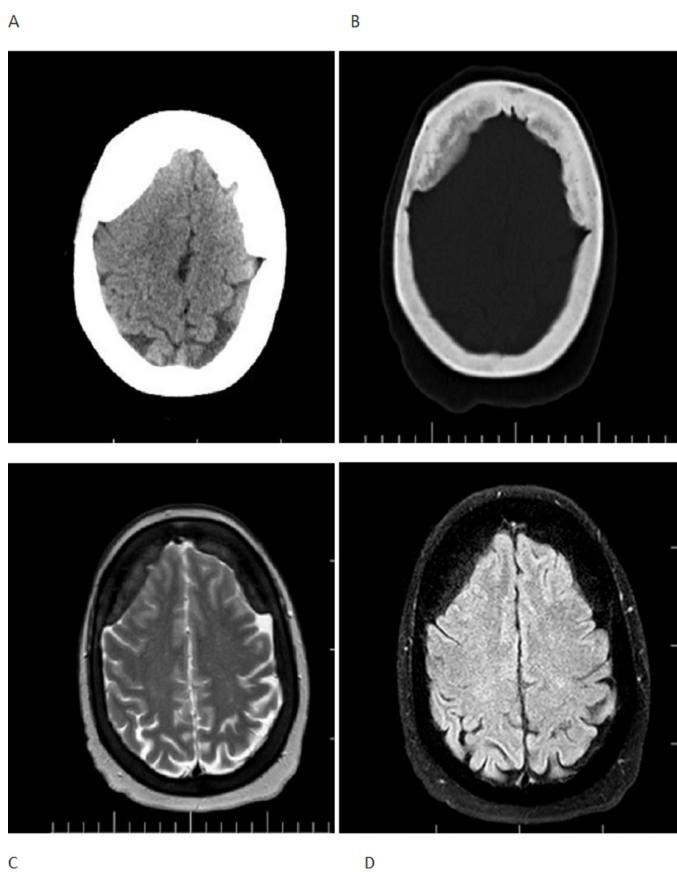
Computed tomography (A and B) and Magnetic rezonance image (C and D) done in showing bilateral calcified/ossified chronic subdural haematoma
